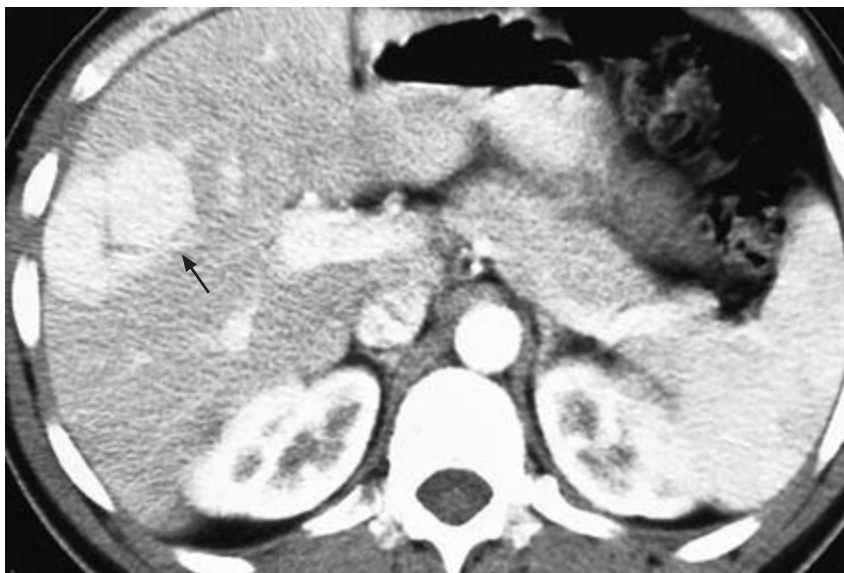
Focal nodular hyperplasia. CT scan, enhanced with intravenous contrast, shows a focal hepatic lesion 5.8 cm in diameter with a central scar (arrow) in the right lobe.
